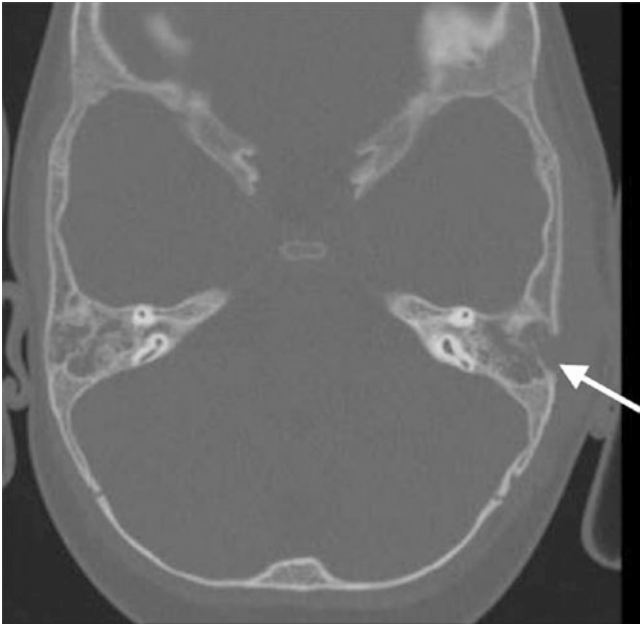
Left coalescent mastoiditis. Axial CT image demonstrates destruction of the lateral wall and septa of the opacified left mastoid (arrow). There is associated retroauricular soft tissue swelling. The right mastoid air cells are also opacified
